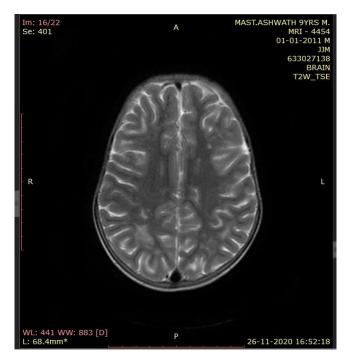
MRI in Younger brother - T2W images showing confluent white matter hyperintensities involving bilateral centrum semiovale with posterior and occipital predominance- s/o white matter demyelination
